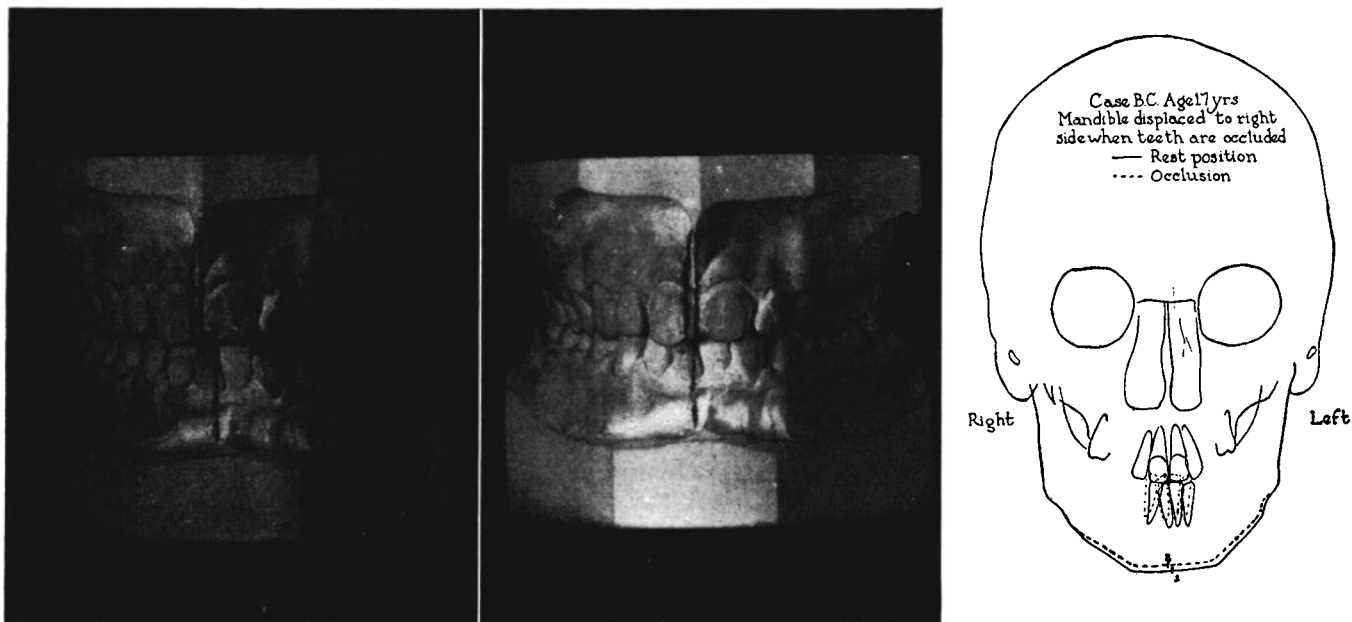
Case B. C., Class I malocclusion. a. Rest position. b. Occlusion. c. Tracing of frontal cephalometric x-ray showing the right lateral mandibular displacement.
